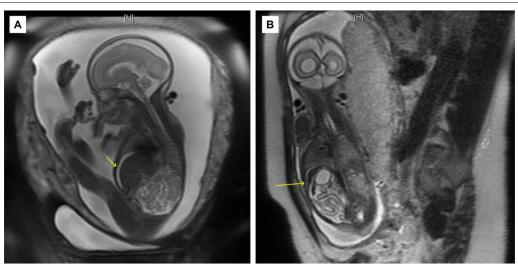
Foetal magnetic resonance imaging (MRI) at 27 weeks of gestation. A: Axial MRI of fluid-filled loops of small bowels noted. There is a moderate volume of ascites with fluid overlying the liver (yellow arrow). B: Coronal MRI of a tubular structure containing high T1 signal at the inferior margin of the right hepatic lobe (yellow arrow). This is consistent with ascending colon atresia, stenosis, and/or perforation. There is no meconium visualised distal to this point. Mild cerebral ventricle asymmetry noted with no significant ventriculomegaly
